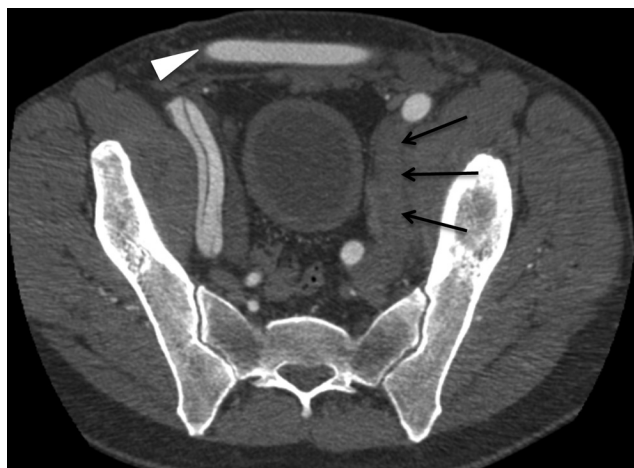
Postoperative computed tomography scan of the pelvic region with intravenous contrast, reformatted image, demonstrating persisting left external iliac artery occlusion (black arrows) and patent femoro-femoral crossover bypass graft (white arrowhead).
